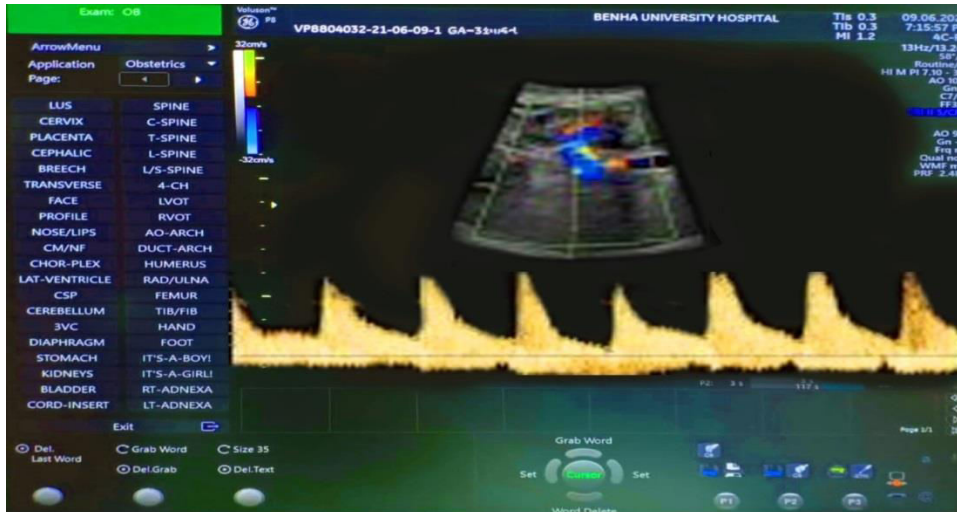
Doppler of a fetal renal artery in a case of oligohydramnios, 43 w, with PI of 2.1 and RI of 0.85.
